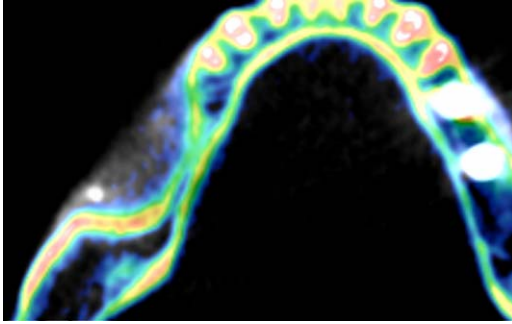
Superimposition of baseline and 7 months CBCT scan.
